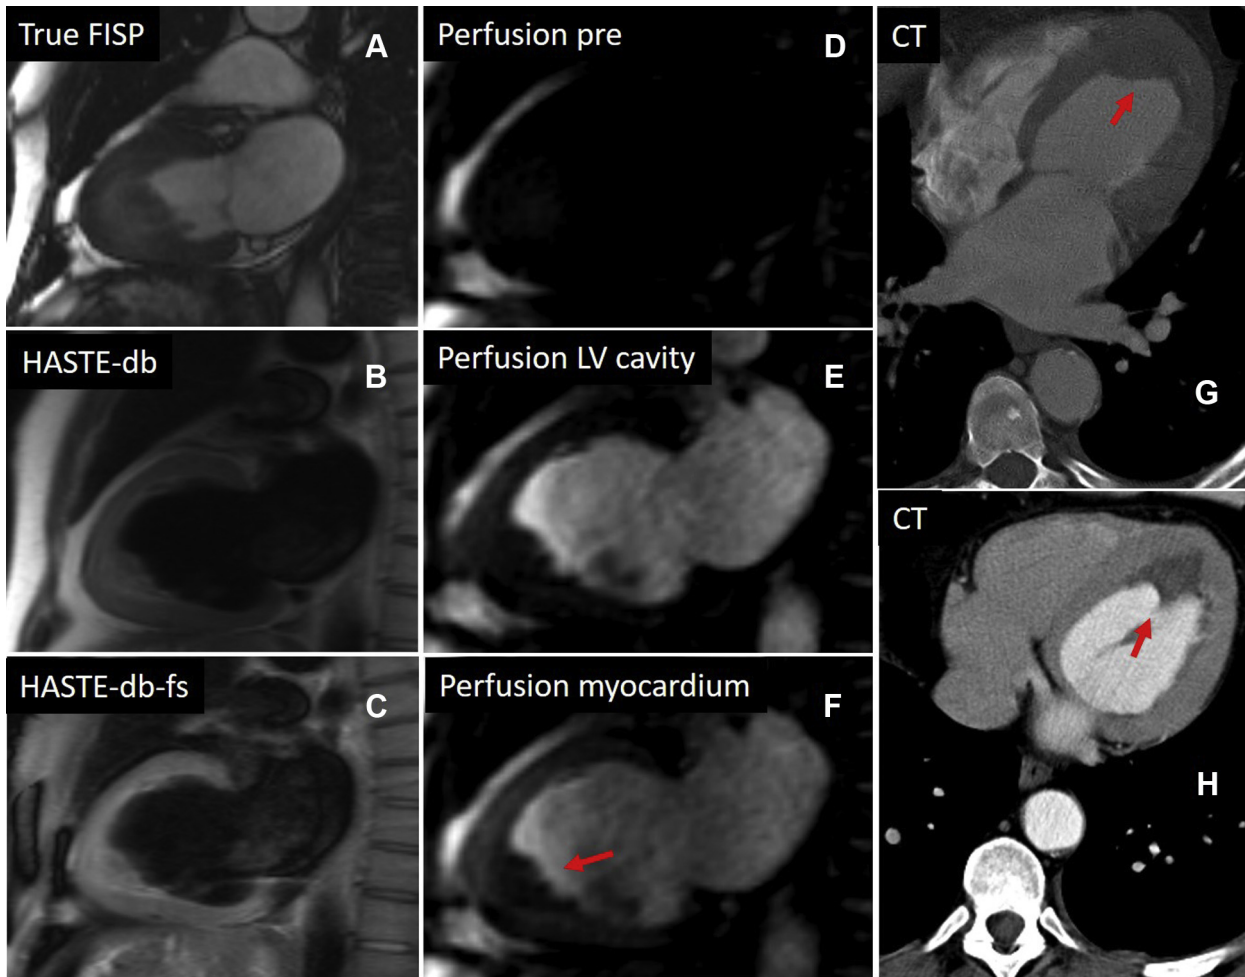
Cardiac magnetic resonance imaging of the two-chamber view (A-F) and cardiac CT of transversal views of the heart (G, H). Cardiac tissue characterization by T1-weighted bright blood image (A) and fast-spin dark blood echo sequences without (B) and with fat saturation (C). Cardiac magnetic resonance perfusion imaging (D-F) documents contrast-enhanced signals in the myocardium and demarcation of subendocardial thrombus formation (red arrow; F). Cardiac CT shows isodense signal intensity of the myocardium and apical LV thrombus (red arrow) without contrast (G) and demarcation of the subendomyocardial thrombus formation (red arrow) with contrast (H). Thrombotic lesions show no contrast enhancement (red arrows). *True FISP*, fast imaging with steady-state free precession; *HASTE-db*, half Fourier acquisition single-shot turbo spin-echo - dark blood; *HASTE-db-fs*, half Fourier acquisition single-shot turbo spin-echo - dark blood - phase-symmetry.
